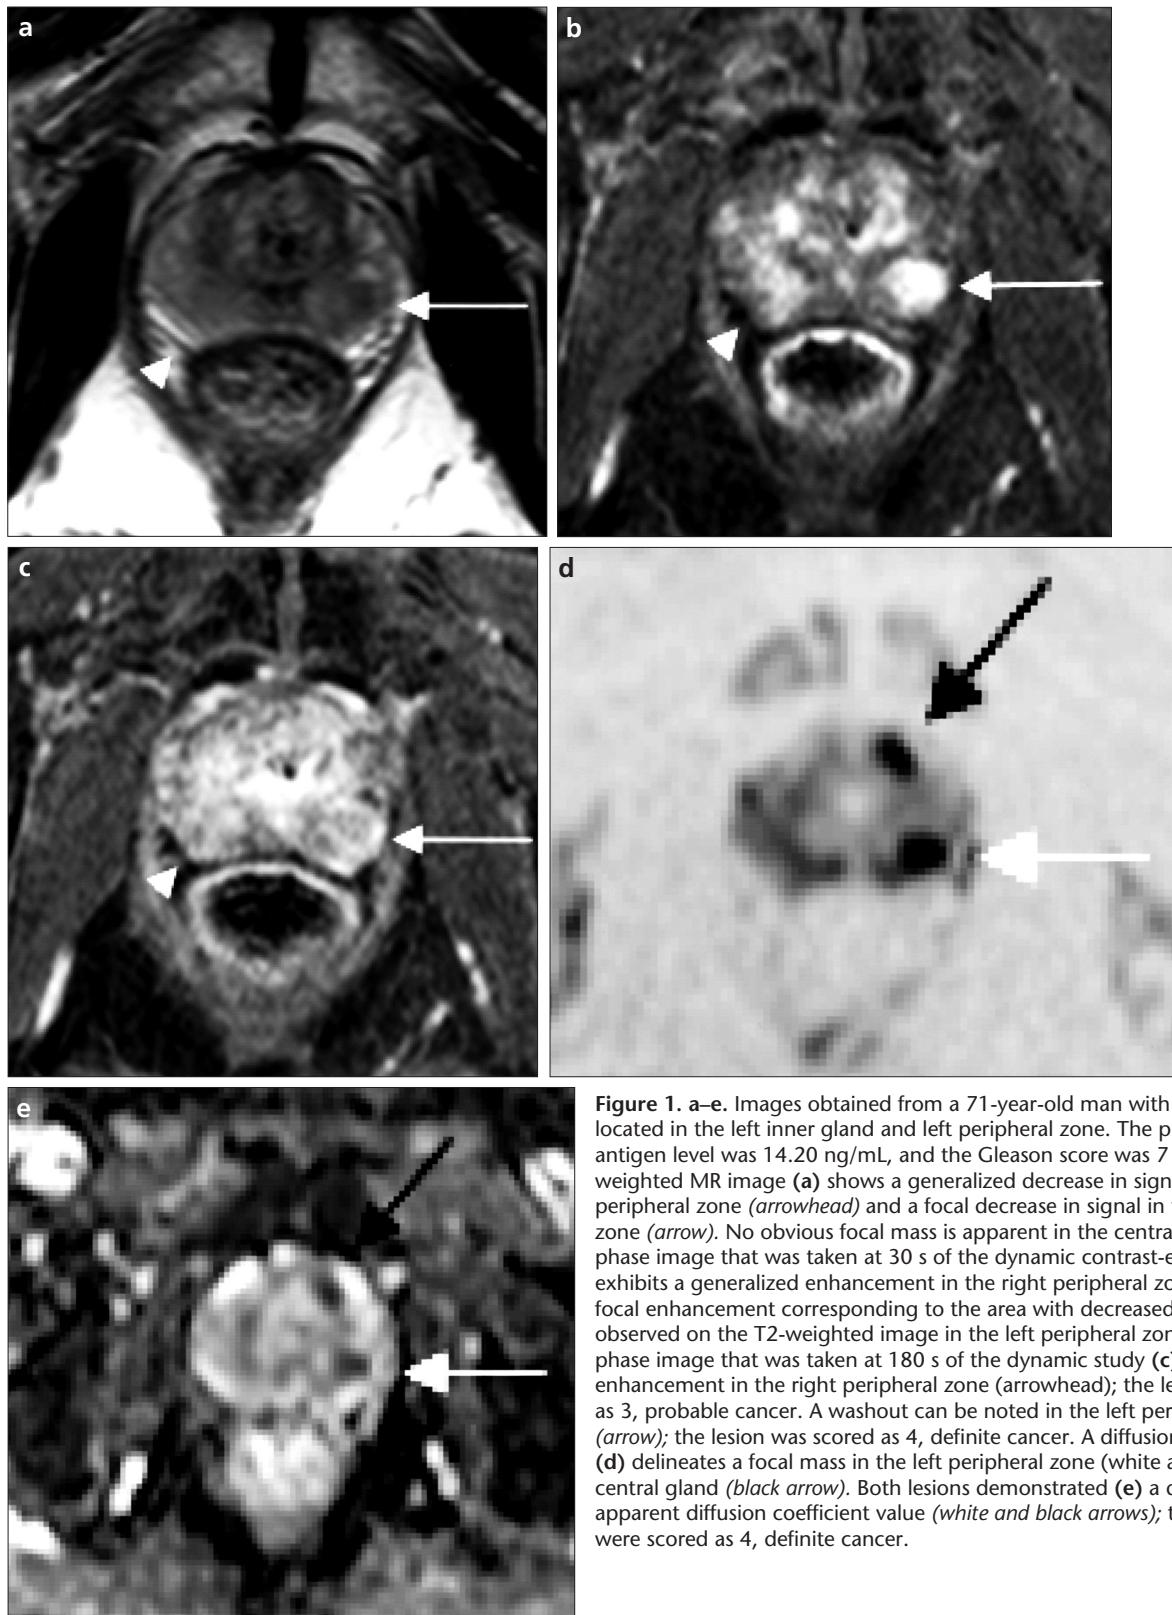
a–e. Images obtained from a 71-year-old man with prostate cancer located in the left inner gland and left peripheral zone. The prostate-specific antigen level was 14.20 ng/mL, and the Gleason score was 7 (3 + 4). A T2-weighted MR image (a) shows a generalized decrease in signal in the right peripheral zone (arrowhead) and a focal decrease in signal in the left peripheral zone (arrow). No obvious focal mass is apparent in the central gland. An early phase image that was taken at 30 s of the dynamic contrast-enhanced study (b) exhibits a generalized enhancement in the right peripheral zone (arrowhead) and focal enhancement corresponding to the area with decreased signal that was observed on the T2-weighted image in the left peripheral zone (arrow). A late phase image that was taken at 180 s of the dynamic study (c) shows prolonged enhancement in the right peripheral zone (arrowhead); the lesion was scored as 3, probable cancer. A washout can be noted in the left peripheral zone lesion (arrow); the lesion was scored as 4, definite cancer. A diffusion-weighted image (d) delineates a focal mass in the left peripheral zone (white arrow) and the left central gland (black arrow). Both lesions demonstrated (e) a decrease in the apparent diffusion coefficient value (white and black arrows); these two lesions were scored as 4, definite cancer.
